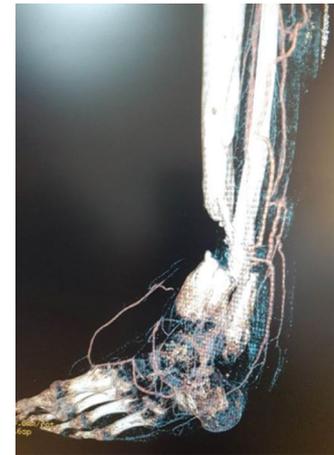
CT with vessel contrast in 3D modeling of the right tibia and foot
